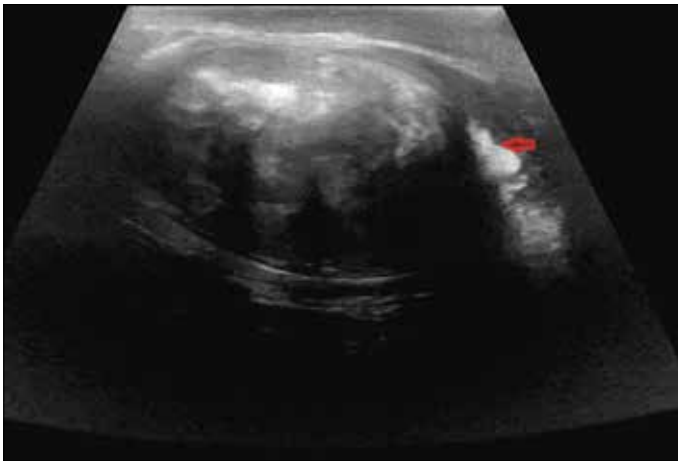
Color Doppler ultrasonography image shows an extratesticular, well-defined, heterogeneous, hypoechoic mass containing hyperechoic foci in the superior part of the left scrotal cavity
